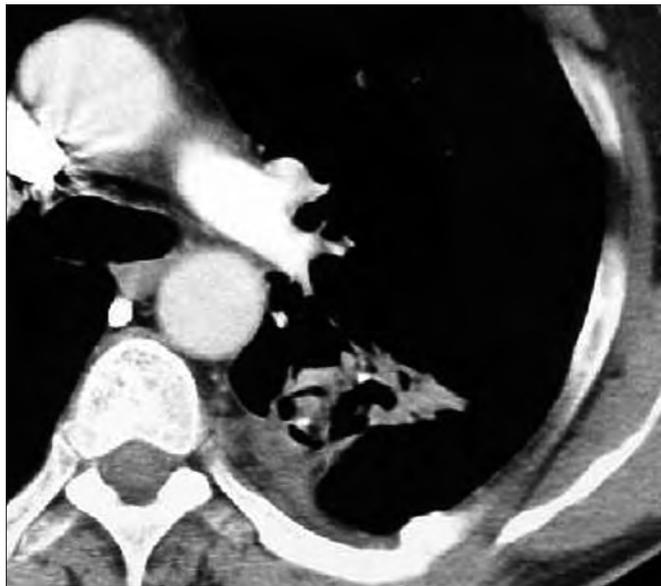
CT image of the ablated lesion of the patient shown in Fig. 1, at mediastinal window setting. The lesion is totally necrotized immediately after the radiofrequency ablation.
